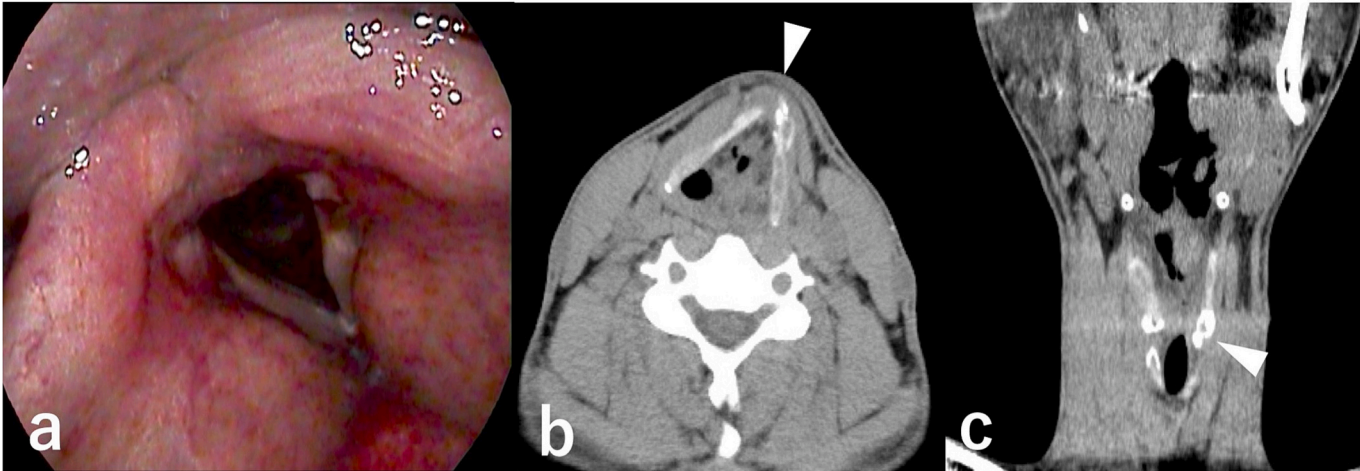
Laryngeal finding after the surgery (a) and CT imaging (b,c). White arrow heads showed that the thyroid cartilage fracture had been repaired.
